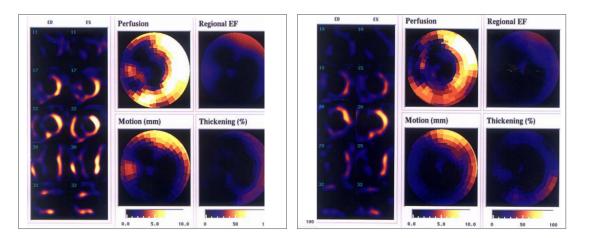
M*, 63 y, DM, retrosternal pain. SPECT-gated in stress and rest - large, irreversible defect which occur in almost entire territory of LAD; large area of moderate hypoperfusion almost entirely reversible in the posterior wall; absence of motility in inferior wall (stunning?); lowering of regional and global LVEF; low global motility and systolic thickening
